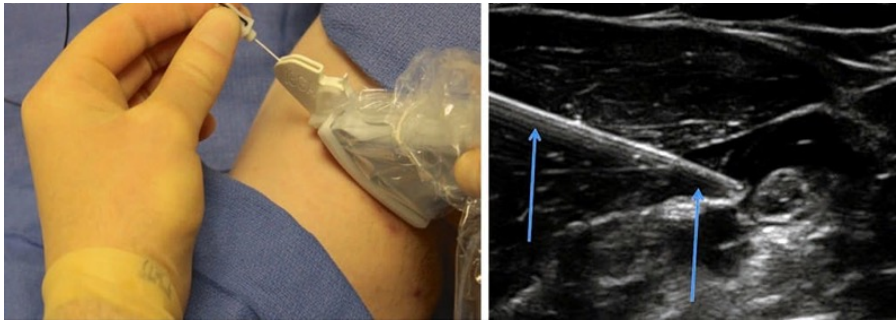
Needle visibility during ultrasound-guided regional anesthesia.
